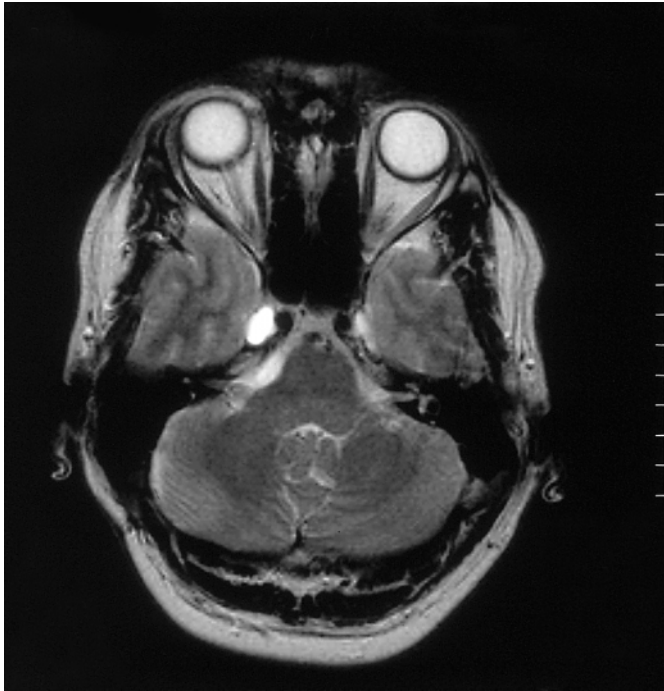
Recurrence of the arachnoid cyst with extension to cerebellopontine angle (MRI, T2, slice-thickness 5 mm).
